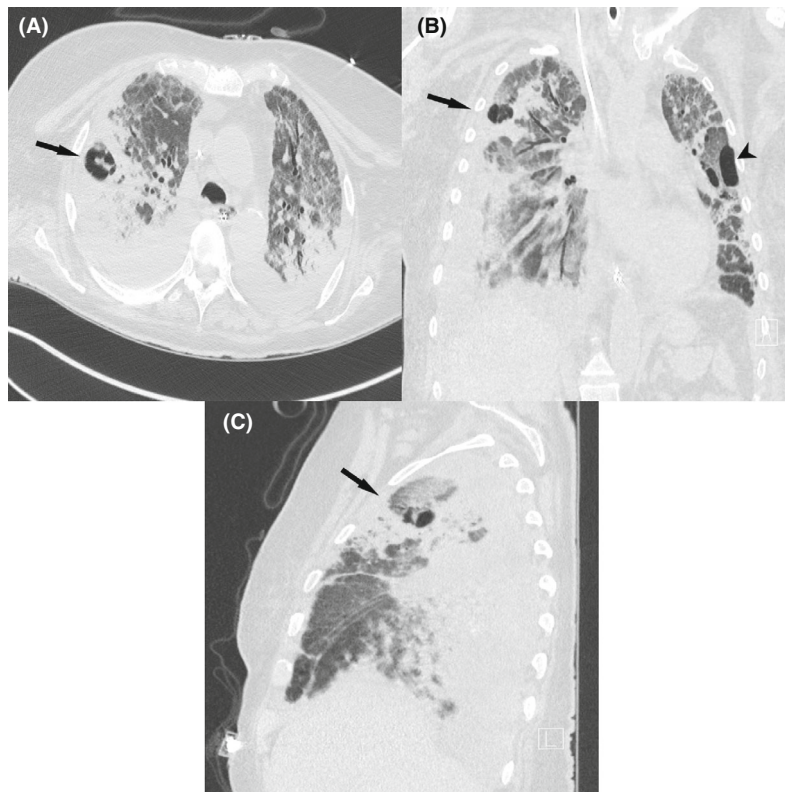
Five weeks after submission with COVID-19. HRCT: Cavitating infiltrate in the right upper lobe (black arrow) and bilaterally pneumatoceles (black arrowhead) not seen previously. Widespread consolidations dominate the image, and the remaining lung parenchyma is seen with ground glass opacification. Bilaterally pleural effusion is present. (A) Axial lung window, (B) coronal lung window and (C) sagittal lung window.
